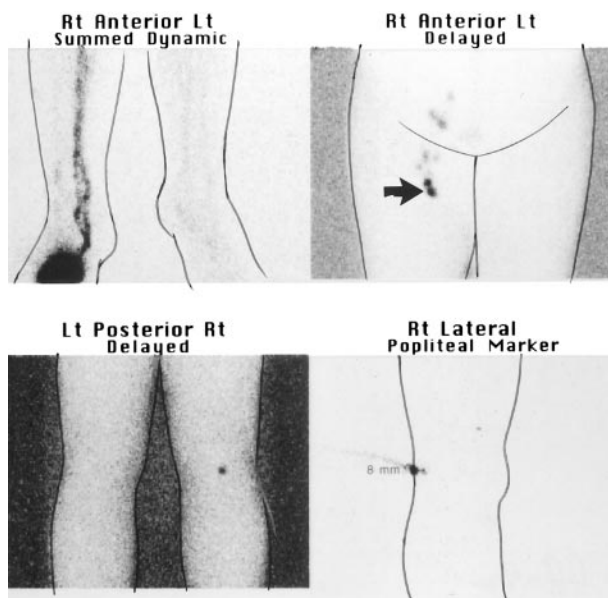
Dynamic (top left) and delayed lymphoscintigraphy (top right, bottom left and right) in a patient with a melanoma excision biopsy site on the dorsum of the right foot. Two bright and one faint lymphatic collecting vessels pass up the leg on the dynamic image; these drain to a single sentinel node in the right popliteal fossa and two sentinel nodes in the right groin (arrow). Some second-tier nodes are seen above the sentinel nodes in the groin; they are seen more commonly here because lymph flow is more rapid in the leg than elsewhere. An orthogonal view is always performed to measure the depth of the sentinel node from the skin (bottom right).
